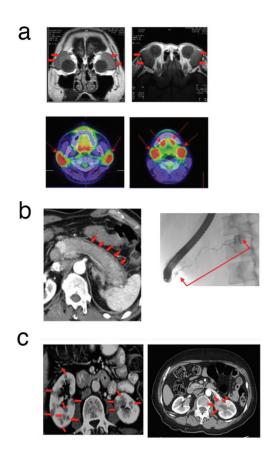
IgG4-RD. (a) IgG4-related dacryoadenitis, sialadenitis and parotitis (so-called IgG4-related MD). MRI (upper) and PET (lower). (b) IgG4-related AIP (type I AIP). CT shows swelling of the pancreas (arrows) with hepatic phase enhancement and low-density capsule like rim (left). Pancreatogram shows diffusely irregular narrowing of the main pancreatic duct (right). CT and X-P films were provided by Dr K. Okazaki (Kansai Medical University). (c) IgG4-related kidney disease (IgG4-related KD). Multiple low-density lesions on enhanced CT (arrows in left) and diffuse thickening of the renal pelvis wall with smooth intraluminal surface (arrows in right).
